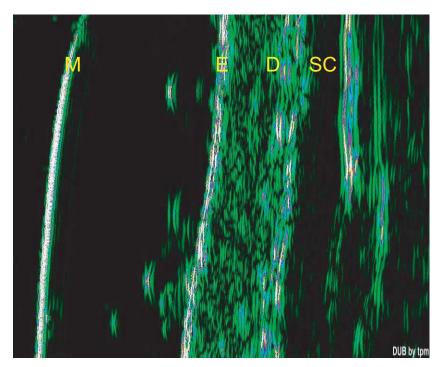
20 MHz ultrasound image of normal skin. M, probe membrane; E, epidermal entrance echo; D, dermis; SC, subcutis and the surrounding intercellular matrix and cells. The subcutaneous space is normally weakly or non-reflecting, so that the interface with the dermis is well defined.
